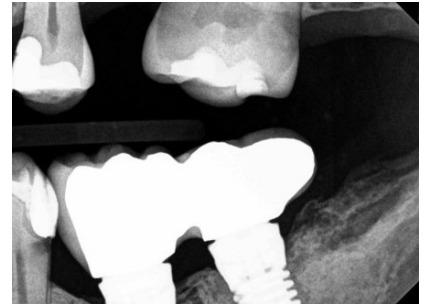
This is an x-ray image of Figure 15 in the mouth with open margins under the crown profiles.
